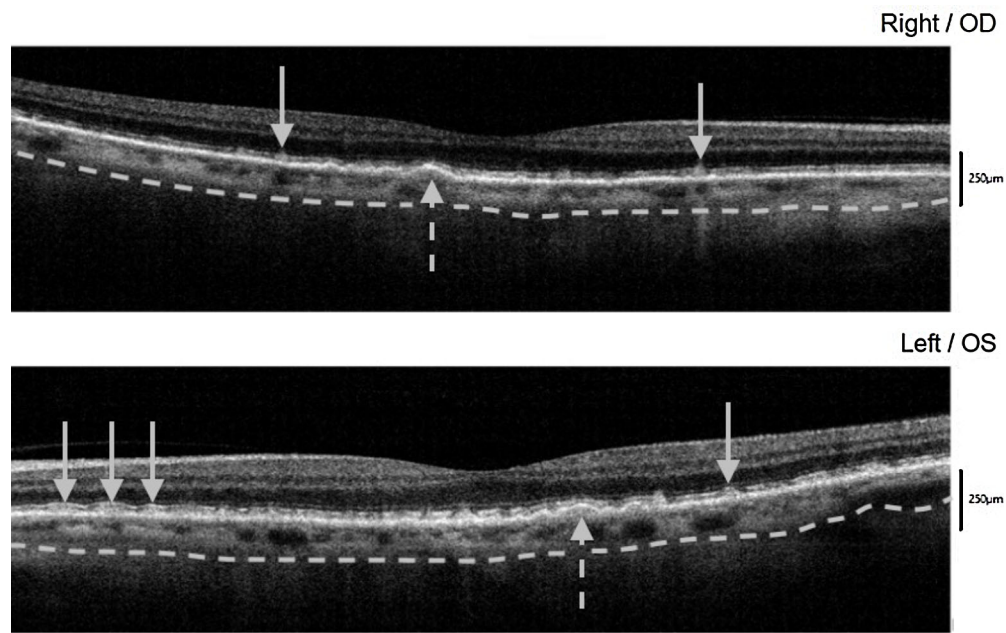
SD-OCT imaging of SDDs (*solid arrows*) and soft drusen (*dashed arrows*) in a patient with ischemic stroke and bilateral ICA stenosis on CT head and neck (100% stenosis of the right ICA, 50% stenosis of the left ICA). SDDs of Stages 1, 2 and 3 appear as hyper-reflective material above the retinal pigment epithelium (RPE) and below, elevating and penetrating the EZ, respectively. Stage 1 SDDs are numerous in both scans. Three Stage 2 SDDs elevating the EZ are seen on the left in the scan of OS. A Stage 3 SDD penetrating the EZ is seen at the right in the scan of OD. Soft drusen are found below the RPE in both scans. The *gray dashed lines* demarcate the choroidal-scleral interface. This patient had at least moderate ICA stenosis, thin choroids (<250 μm), drusen, and SDDs bilaterally.
